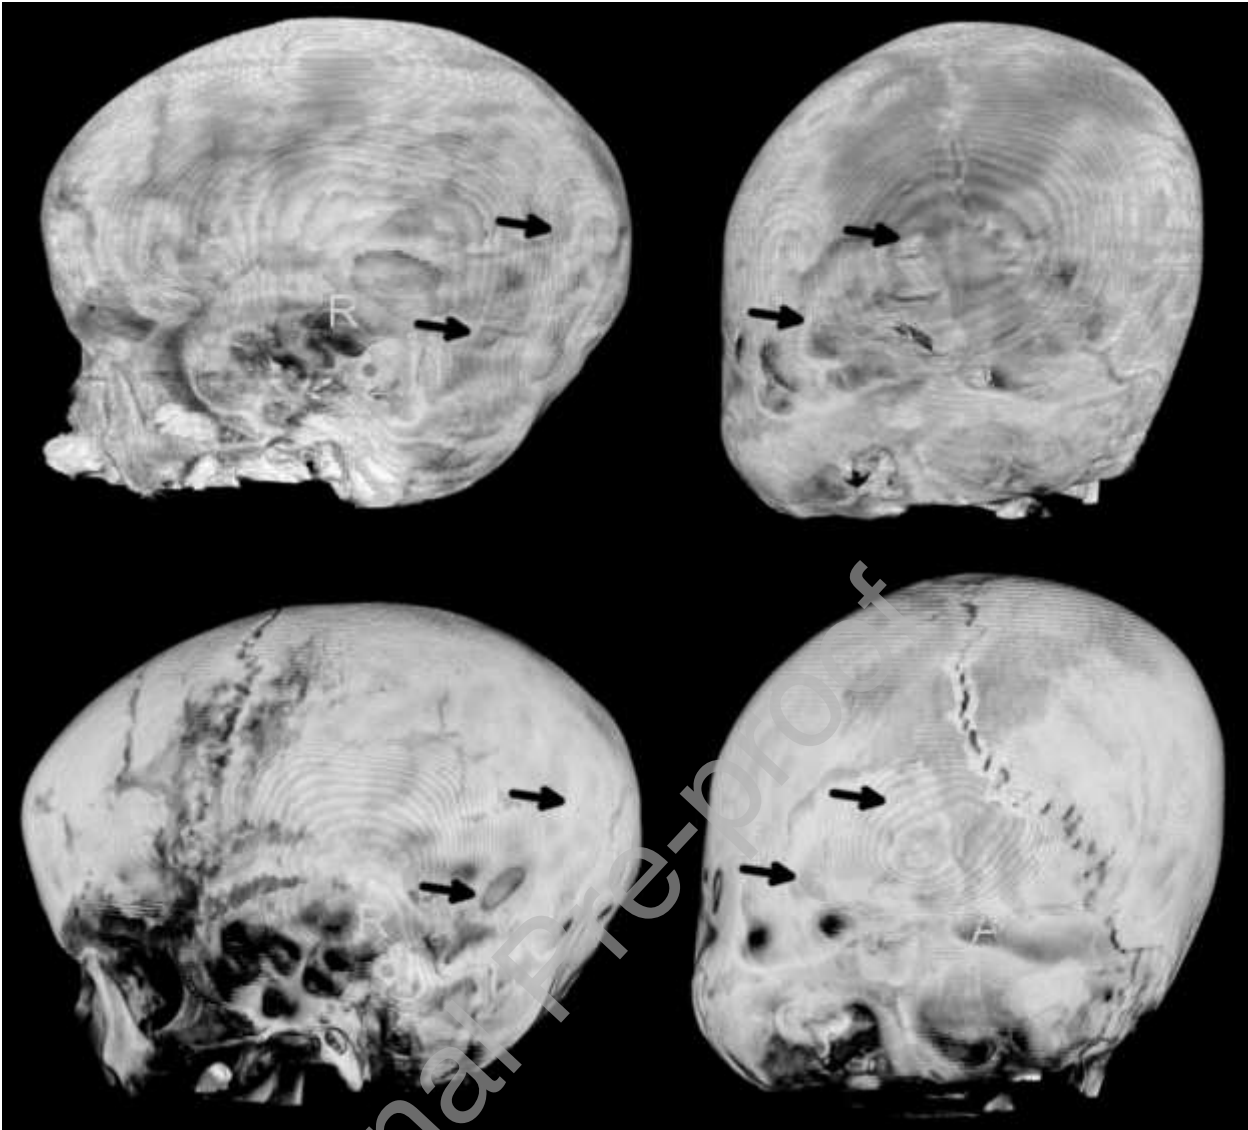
Skull images of patient 7 with left lambdoid synostosis. Top row, 3D-rendered BB-MRIs at the age of 78 months. Bottom row, 3D-rendered CT images at the age of 76 months. The arrows point to the location of the fused suture.
